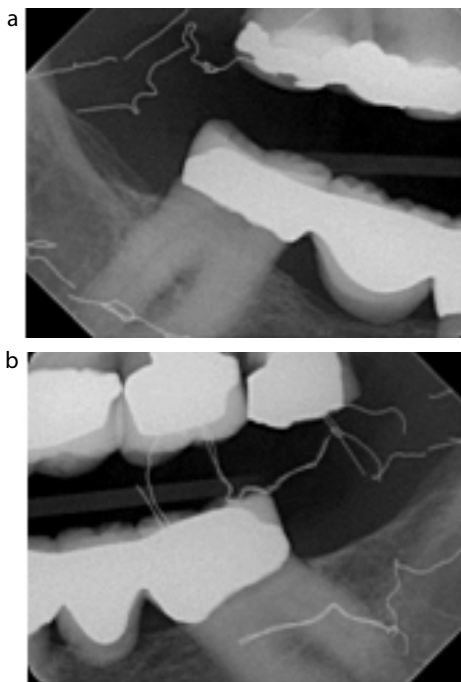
(a) Right bitewing radiograph taken 01/09. (b) Left bitewing radiograph taken 01/09.
